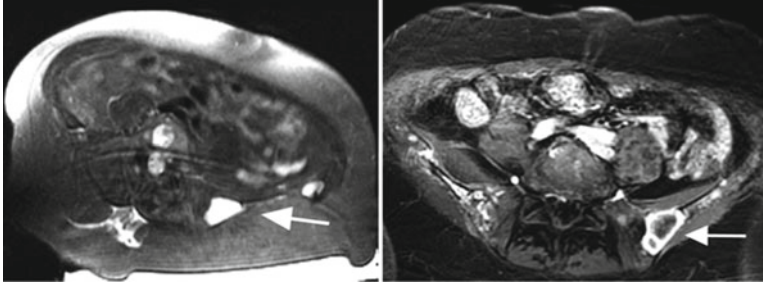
A patient from the study done by Gianfelice et al. [23] contrast-enhanced T1-weighted MR images pre-treatment (*left*) and post-treatment (*right*) show the medullary component of the osteolytic metastasis of the *left* iliac bone and the necrotic lesion
